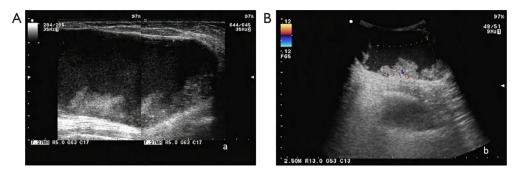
Ultrasound results from a 42-year-old patient with MBC. (A) The two-dimensional ultrasonic performance of MBC included big size, regular shape, circumscribed margin, cystic and solid echo pattern, and posterior acoustic enhancement; (B) the vascularity grade of MBC was grade II. MBC, metaplastic breast carcinoma.
